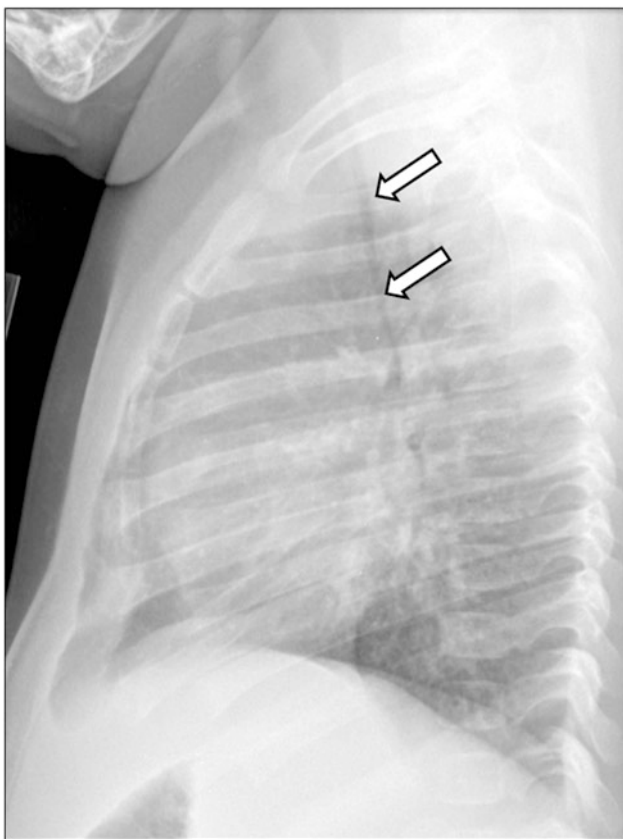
Tetralogy of Fallot with absent pulmonary valve and aneurysmal dilatation of left pulmonary artery in a neonate boy who presented with severe respiratory distress. Axial lung window CT image (a), 3D volume rendered image (b), and minimum intensity projection image (c) show an aneurysmal dilatation of the left
